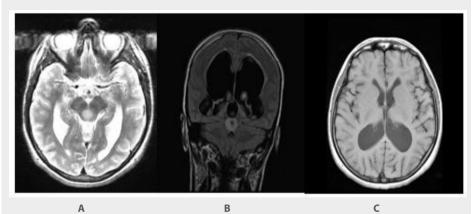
Patient 5. *A*: Transversal T2-weighted MRI image showing a hyperintense periaqueductal tumour lesion *B*: Coronal section of a MRI Flair image of a tectal plate tumour and obstructive hydrocephalus before ETV C: Transversal T1-weighted MRI image of the same patient after ETV
